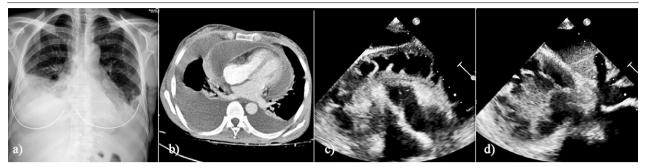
a) Chest X-Ray showing both sinuses obliterated by pleural fluid; b) Computer tomography of the chest showing both sinuses obliterated with pleural fluid and pericardial cavity filled with dense fibrinous material; c) and d) Pericardial effusion with dense fibrin materials around the heart.
